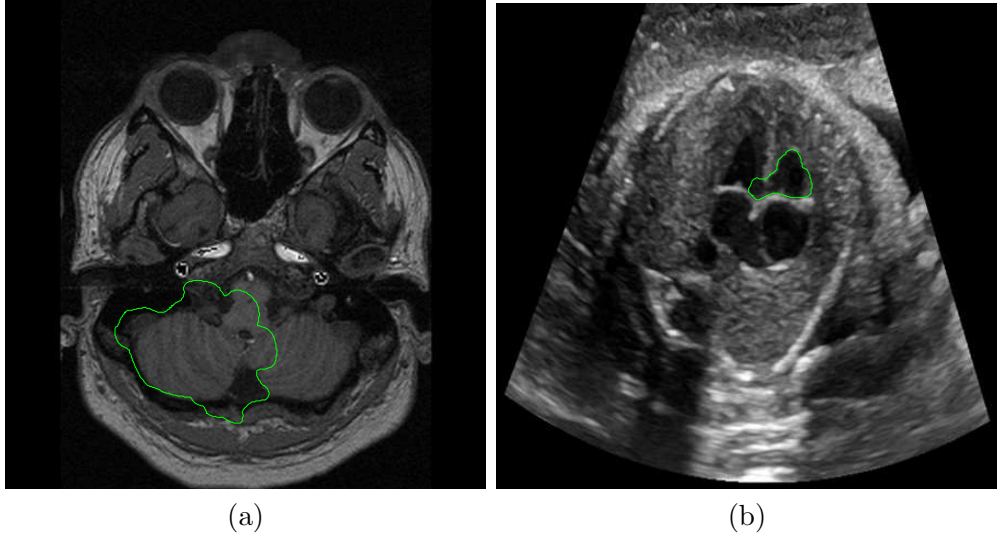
Example of medical image segmentation with weak edges and using GVF active contour. (a) CT slice of skull. (b) 4 Chamber Heart Ultrasound.
